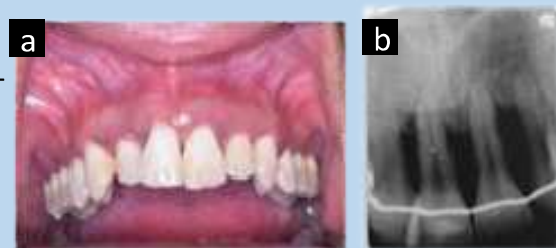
Clinical (a) and radiographic (b) images of the anterior teeth three years post the traumatic dental injury.
